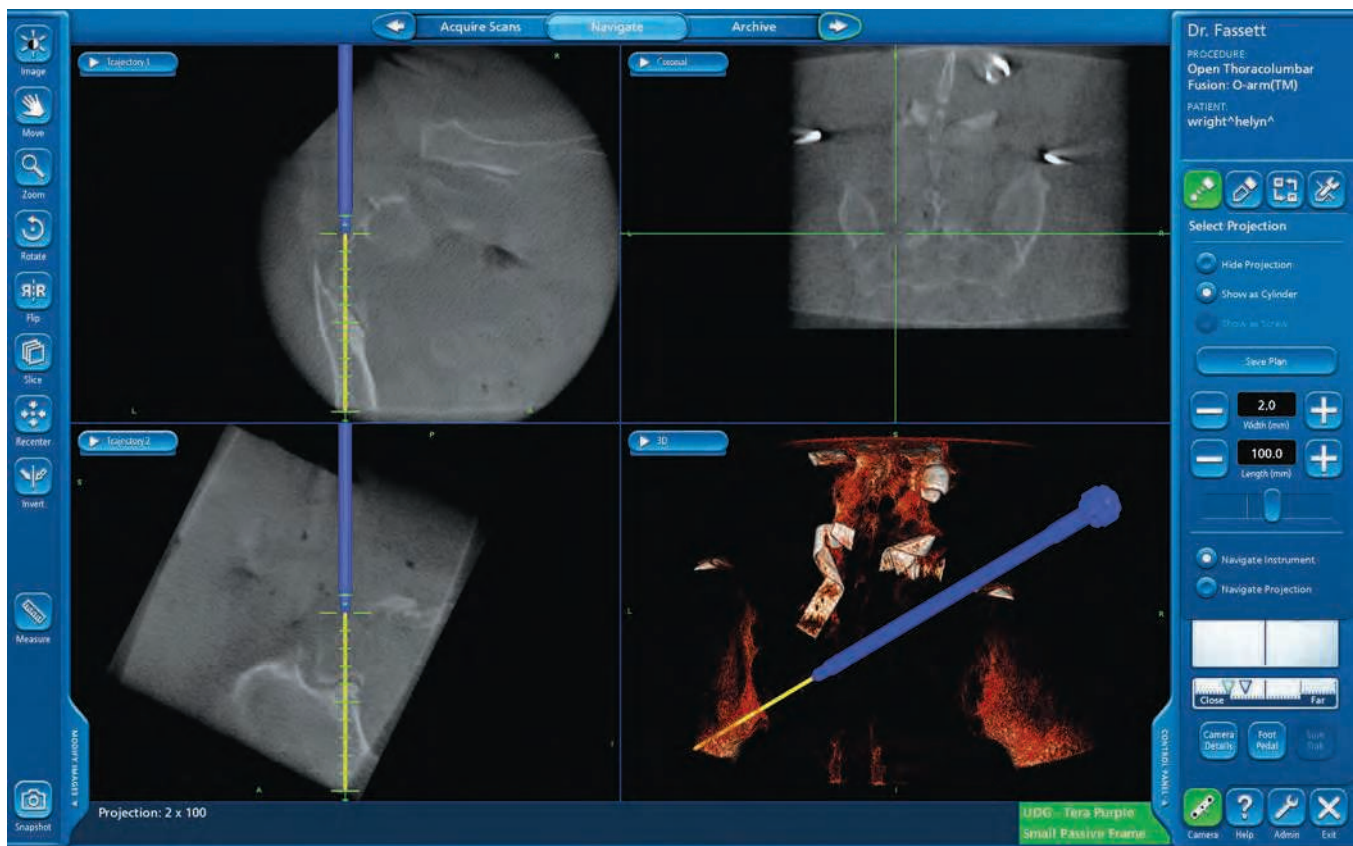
Images of intraoperative CT (O-arm®)-based navigation for placement of sacral alar-iliac screws. Note the ideal projection of the screw crossing the SI joint right above the sciatic notch in the “in-line” trajectories (superior and inferior left) and coronal plane (superior right) as well as anteroposterior radiographic projection).
